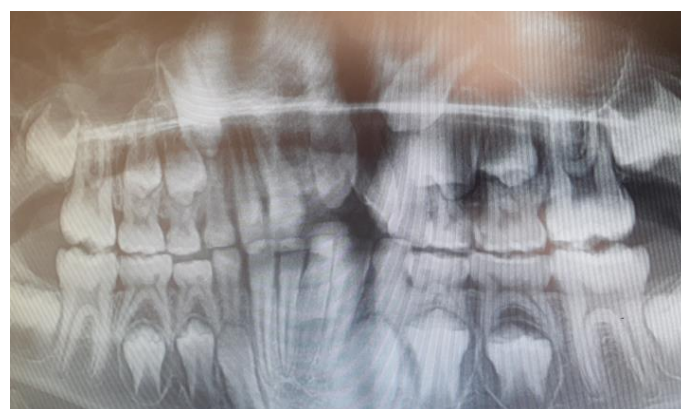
Radiographic Image.
